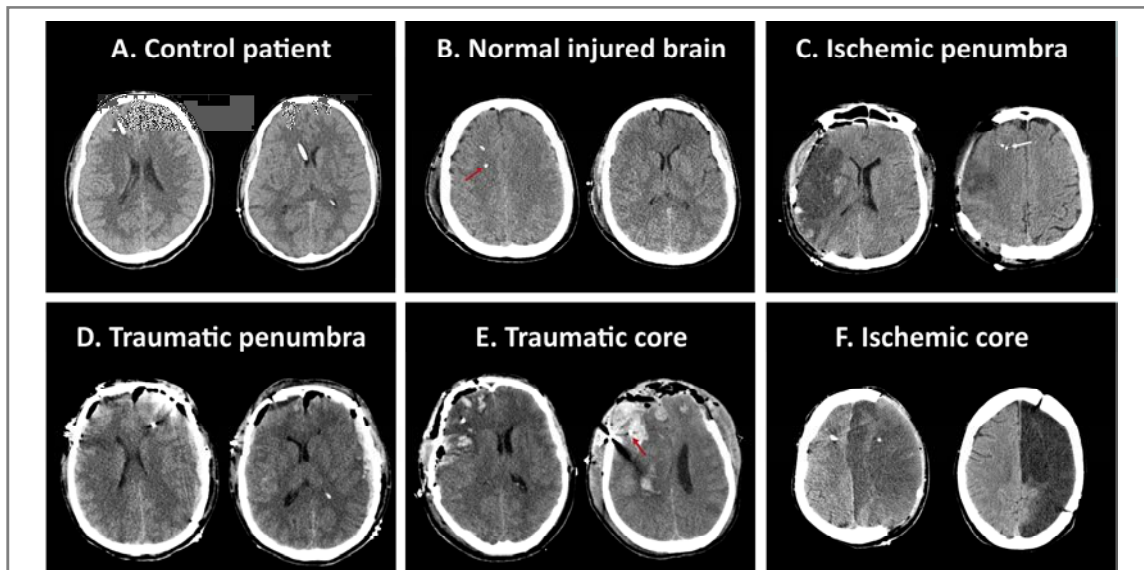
Examples of computed tomography (CT) images for the categories of brain tissue defined according to the placement of the cerebral microdialysis (MD) catheter.
